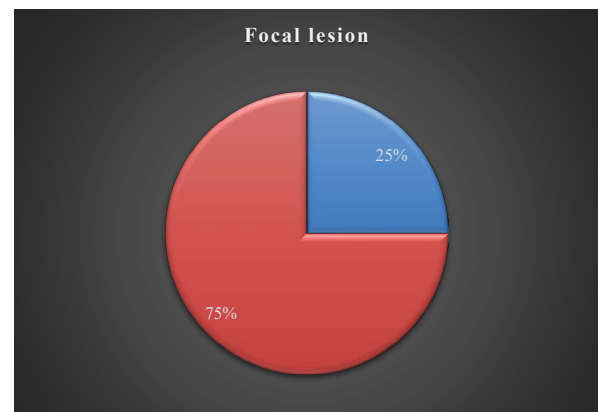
Distribution of the study subjects by sonographic estimation of focal lesion after 6 months post operative period (n=12).
